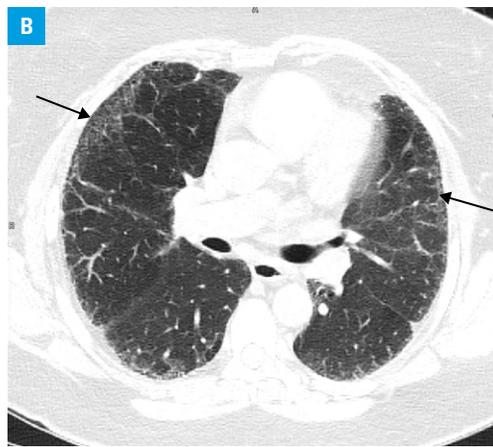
B, C – chest computed tomography in the axial view showing a subpleural and peripheral reticular pattern (B, arrows) and a small area of honeycombing (C, arrow); D – chest computed tomography in the sagittal view showing reduced lung volume, a subpleural reticular pattern, and honeycombing (arrow)
